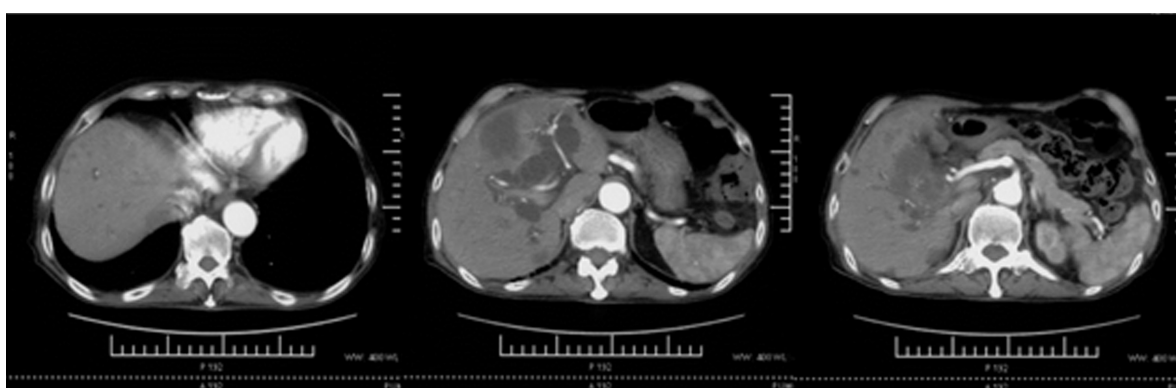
Two and half months post-olaparib treatment (October 9, 2015). Computed tomography of the abdomen indicated that intrahepatic lesions dwindled; nevertheless, extrahepatic lesions became large and progressed.
